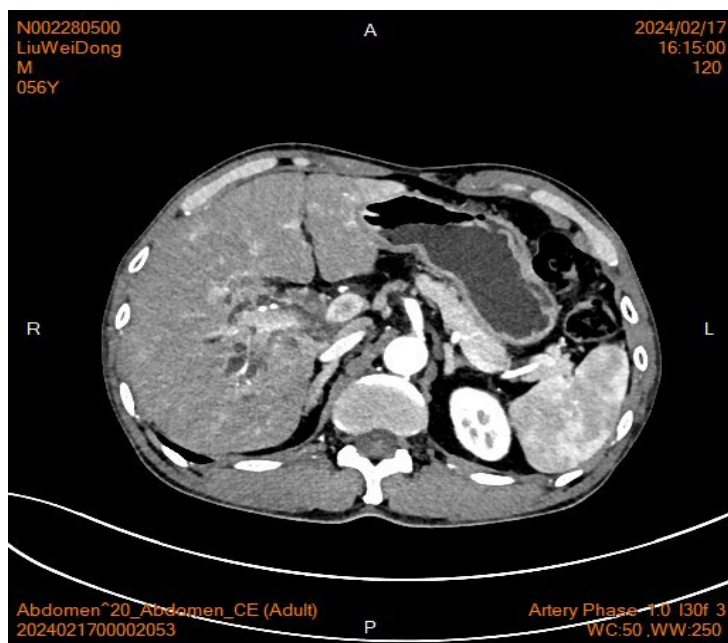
CT demonstrates: abnormal cast-like density in the hepatic hilar region and bile ducts of the right hepatic lobe
